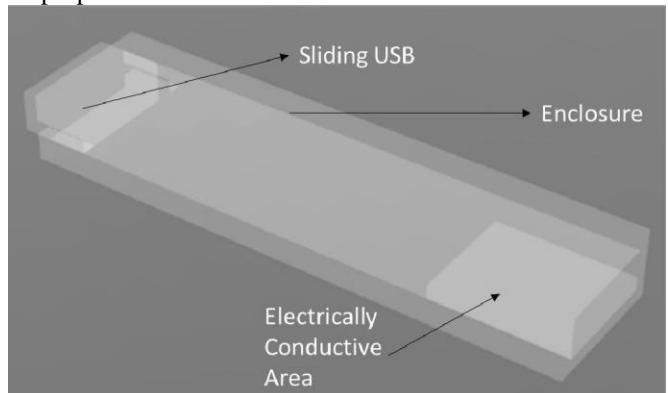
X-Ray view of 3D CAD Model of the proposed concept
